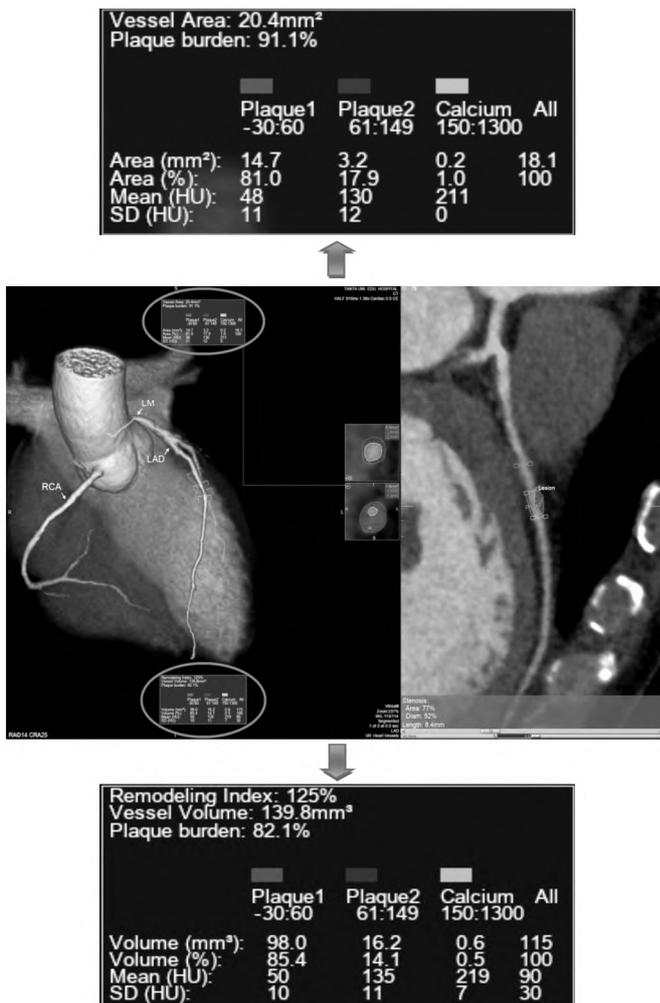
Semi-automated quantitative coronary plaque analysis revealed fibrofatty plaque with predominate lipid component (calcium = 0.5 %). Plaque characterization at area of maximal plaque burden revealed high risk plaque characteristics; positively remodeled non calcified lesion (1.25) with Plaque burden > 0.7 (91.1%), NRS (inner hypodense lipid core representing 81.0 % of plaque area, CT number  $48 \pm 11$  and hyper dense fibrotic outer rim with spotty calcification seen within its outer rim, CT number  $130 \pm 12$ ).
